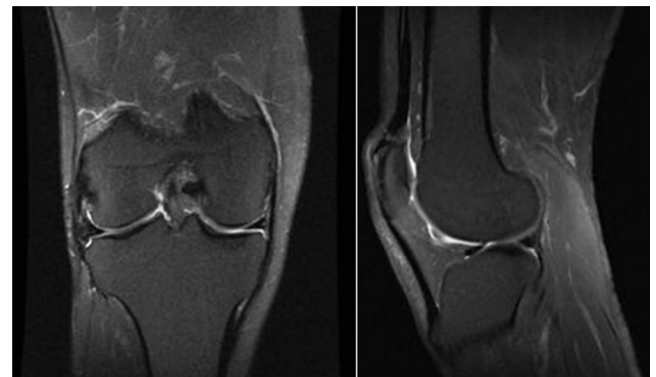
Type I images on MRI; patient treated for lesions in the middle and posterior segments of the lateral meniscus.
